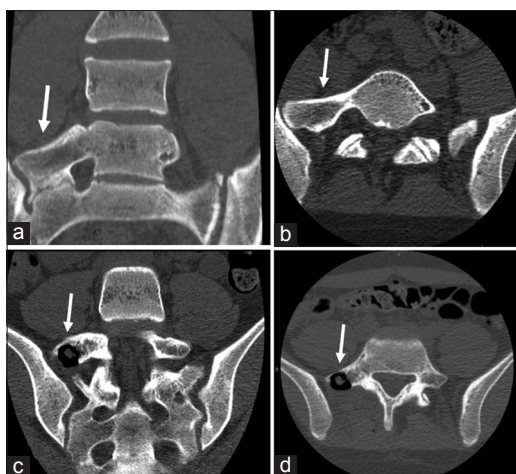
Preoperative coronal computed tomography (CT) (a) and sagittal CT (b), both demonstrating a sacralized L5 with pseudoarthrosis from L5 to S1 and the ilium (white arrows). Postoperative coronal CT (c) and axial CT (d), indicating removal of the abnormal articulation (white arrows).
